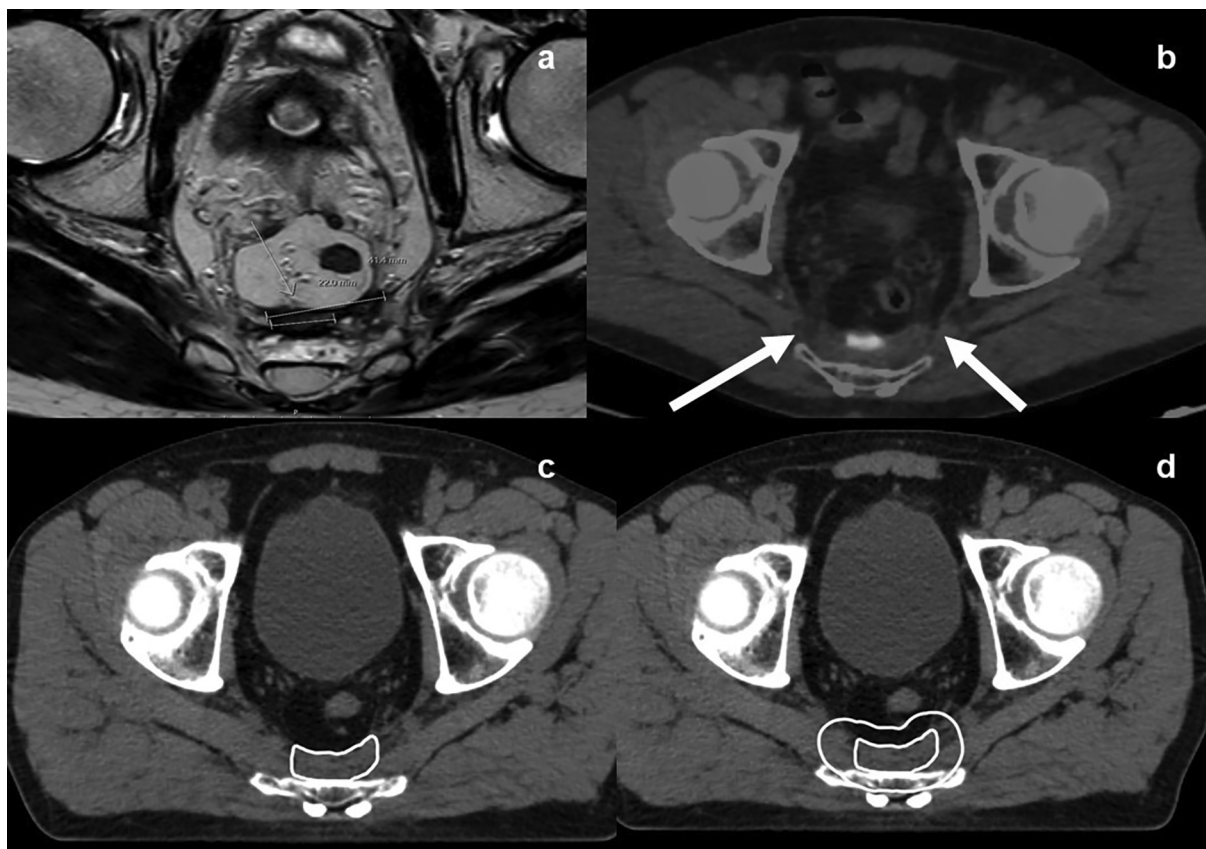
Consensus delineation for case 1.2 (and 2.1). A: MRI imaging of local recurrence. B: PET imaging of local recurrence, surgical at-risk regions (i.e., sacrospinal ligament) highlighted by white arrows. C: GTV delineation (complete fibrosis). D: CTV delineation (GTV + 1 cm, expanded to encompass at-risk surgical region).
